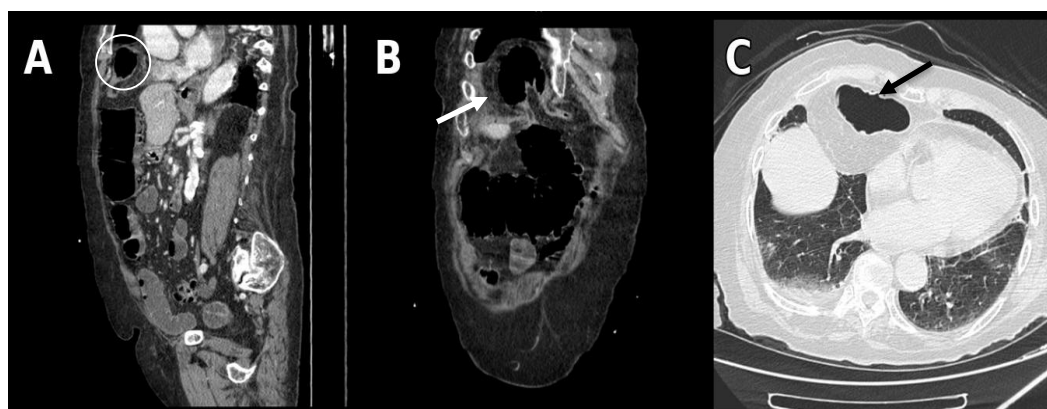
Computed tomography of the chest and abdomen. A. Sagittal section. An ascending colonic loop is observed in the anterior mediastinum (white circle). B. Coronal section: The diaphragmatic defect through which the colonic loop ascends is visible (white arrow). C. Axial section, lung window: A colonic loop is observed at the thoracic level in the anterior mediastinum (black arrow).
